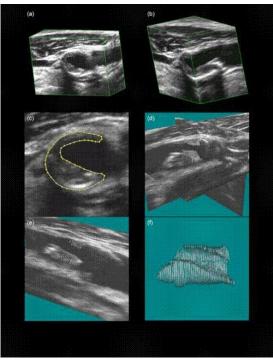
An example of plaque volume measurement using 3-D carotid ultrasound (<u>http://www.imaging.robarts.ca/SPARC/3-</u> <u>D-Plaque-Measurement)</u>
